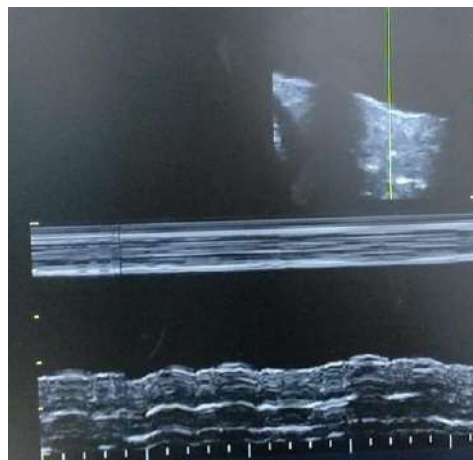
Ultrasonography of lung showing anechoic pleural effusion with thickened pleura (bright white line) and associated collapse of lung (shred sign) in top portion.
